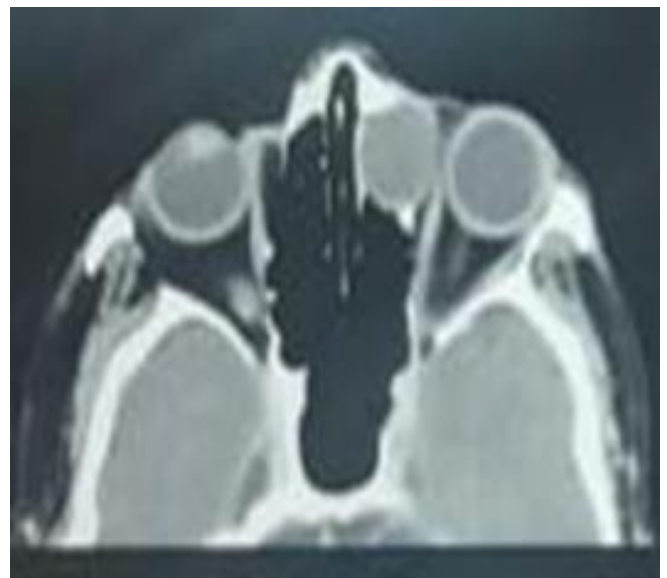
Axial computed tomography image of anterior ethmoidal mucocele
